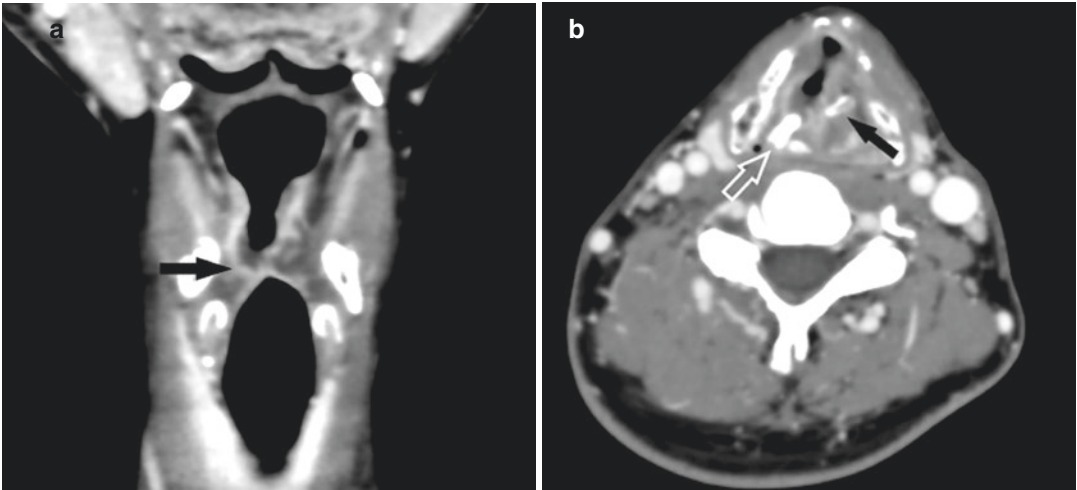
Laryngeal tuberculosis with ulceration and cartilage sclerosis. (a) Coronal contrast-enhanced CT image shows enhancing mucosa of both false and true vocal cords with ulceration and necrotic tissue of the right true vocal cord (arrow). (b) Axial contrast-enhanced CT image
